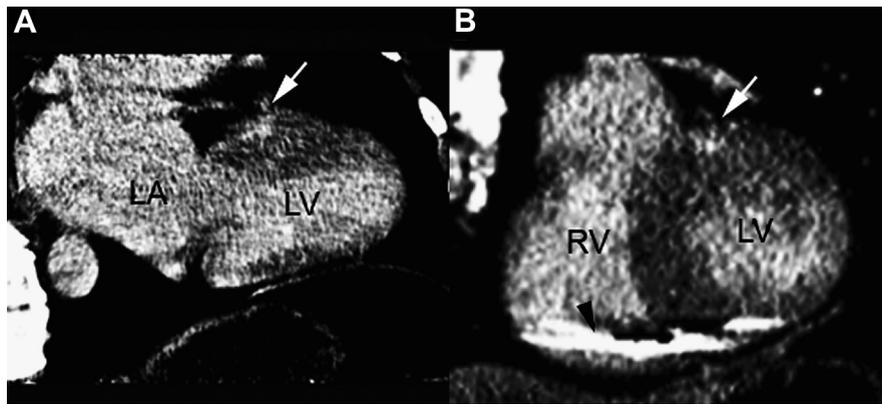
Delayed cardiac CT scan of an 18-year-old male patient with 8.3 g of myocardial fibrosis and no ventricular fibrillation or ventricular tachycardia event shown in 2-chamber (A) and short-axis (B) views. A small area of myocardial fibrosis is present in the anteroseptal region of the left ventricle close to the right ventricular junction (arrows). LA, left atrium, LV, left ventricle, RV, right ventricle.
